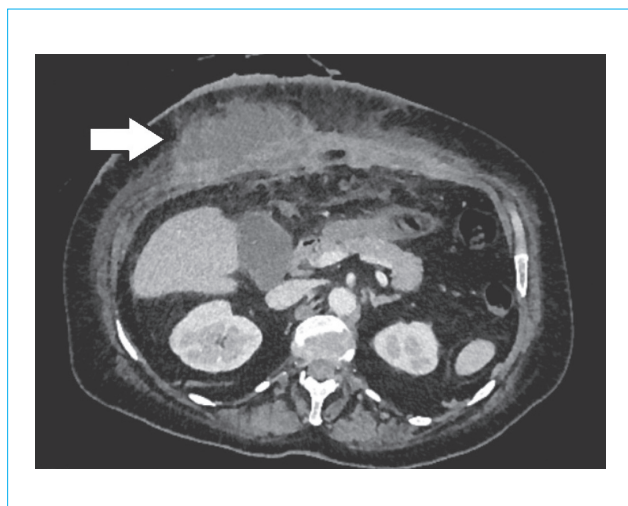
Abdominal contrast-enhanced computed tomography (venous phase) of a 57-year-old patient with diabetes mellitus and complaints of fever, swelling and pain in the anterior abdominal wall. A circumscribed liquid round formation with a thin capsule and perifocal infiltration is determined; during surgery, an abscess of the anterior abdominal wall is confirmed (data obtained by the authors of the article)
